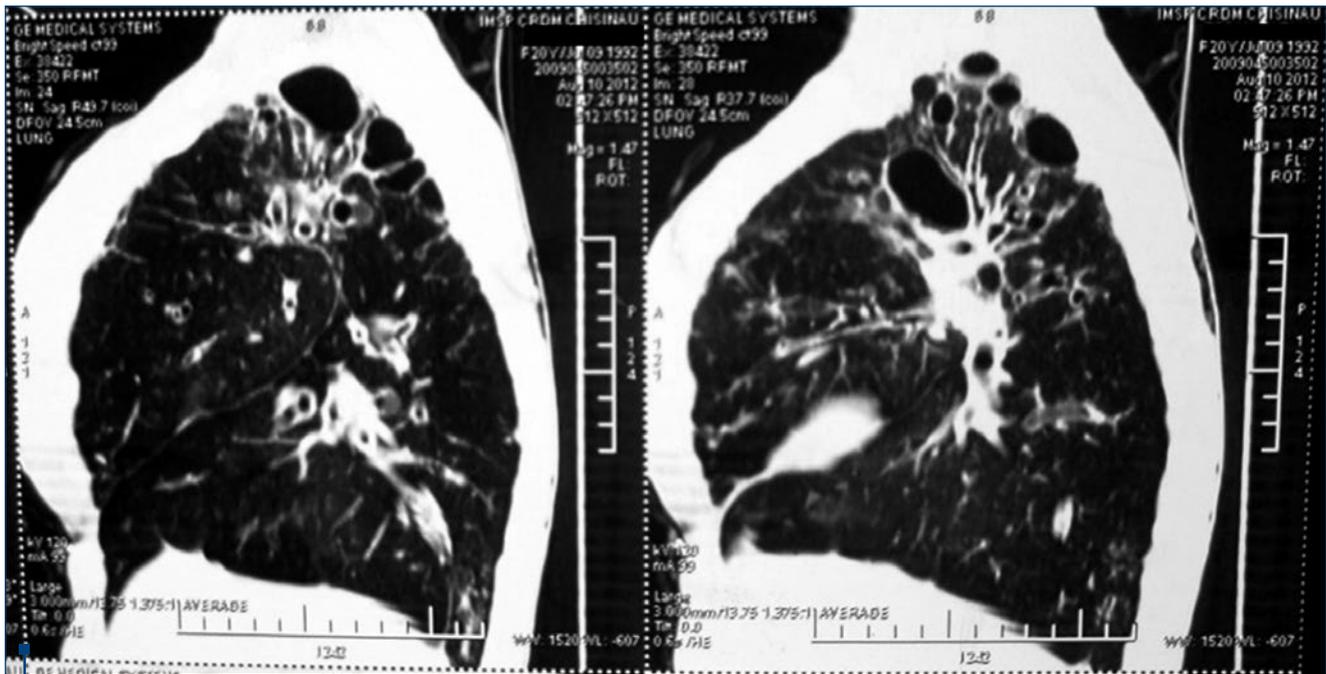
CT of the patient with cystic fibrosis
